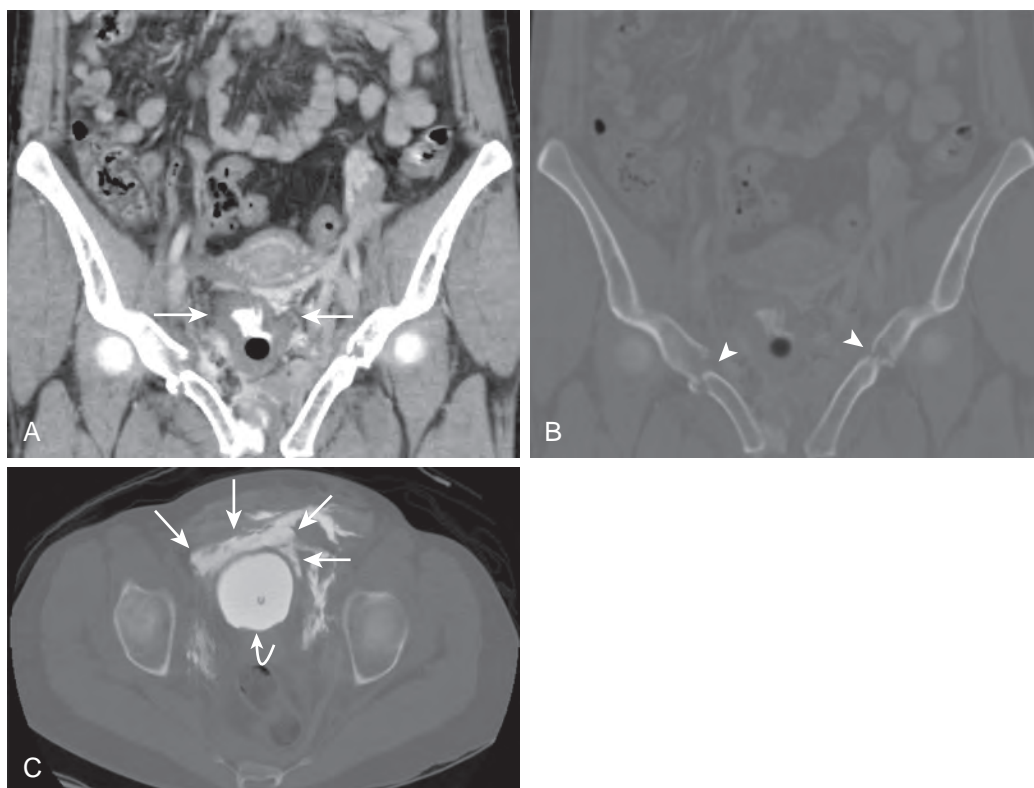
Extraperitoneal bladder rupture. A 51-year-old woman after a motorcycle accident. A. Coronal reformatted CT scan of the abdomen and pelvis revealed extensive pelvic fractures with pelvic hemorrhage. A decompressed urinary bladder with a Foley catheter contains contrast material from initial intravenous injection (*between straight arrows*). B. Coronal reformatted image of the abdomen and pelvis viewed on bone windows shows some of the representative pelvic fractures (*arrowheads*). C. Because of the extensive pelvic trauma, the patient underwent CT cystography, revealing an appropriately distended urinary bladder (*curved arrow*) as well as extravasated contrast material anterior and lateral to the bladder (*straight arrows*). These findings are compatible with an extraperitoneal bladder rupture.
